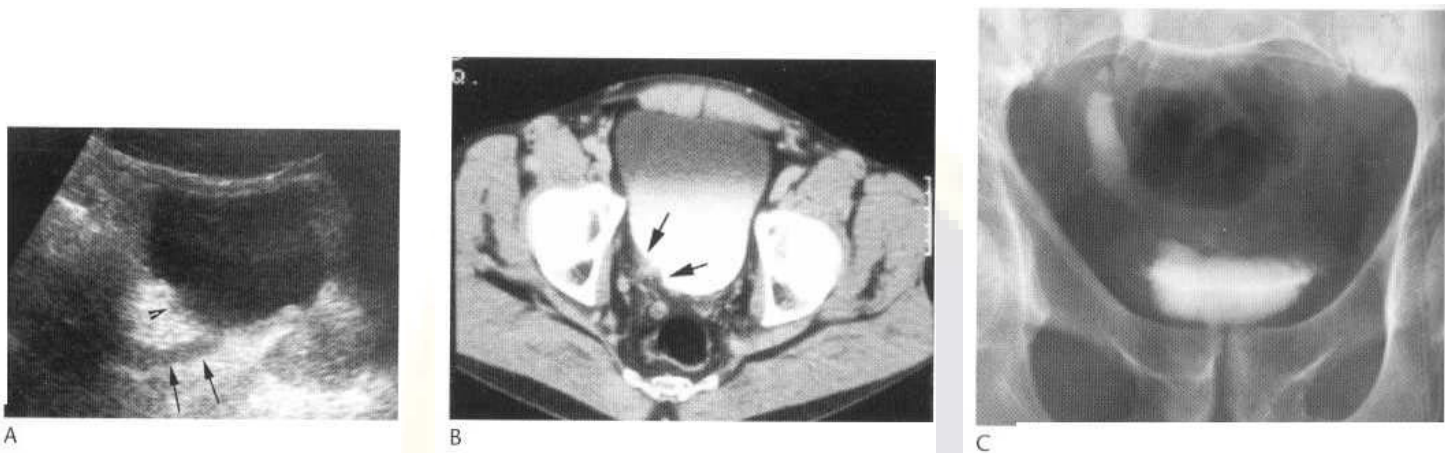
Longitudinal ultrasound of the bladder (A) showing localised wall thickening in tuberculous cystitis (arrowhead) and dilated distal ureter (arrows). Similar heaped-up appearance of the bladder mucosa is seen on CT (B) around the ureteric orifice. The IVU (C) also demonstrates the localised bladder wall thickening, narrowing of the ureteric orifice and dilatation of the distal ureter.
